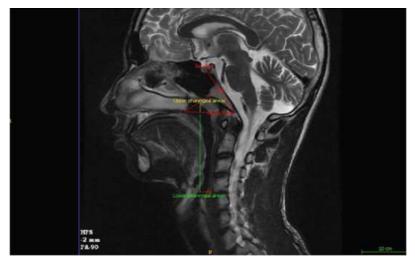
Landmarks of MRI.
